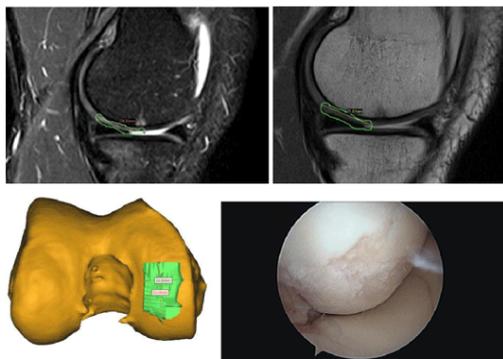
MRI scans of the lesion and 3-D marking – and orthoscopic verification.
